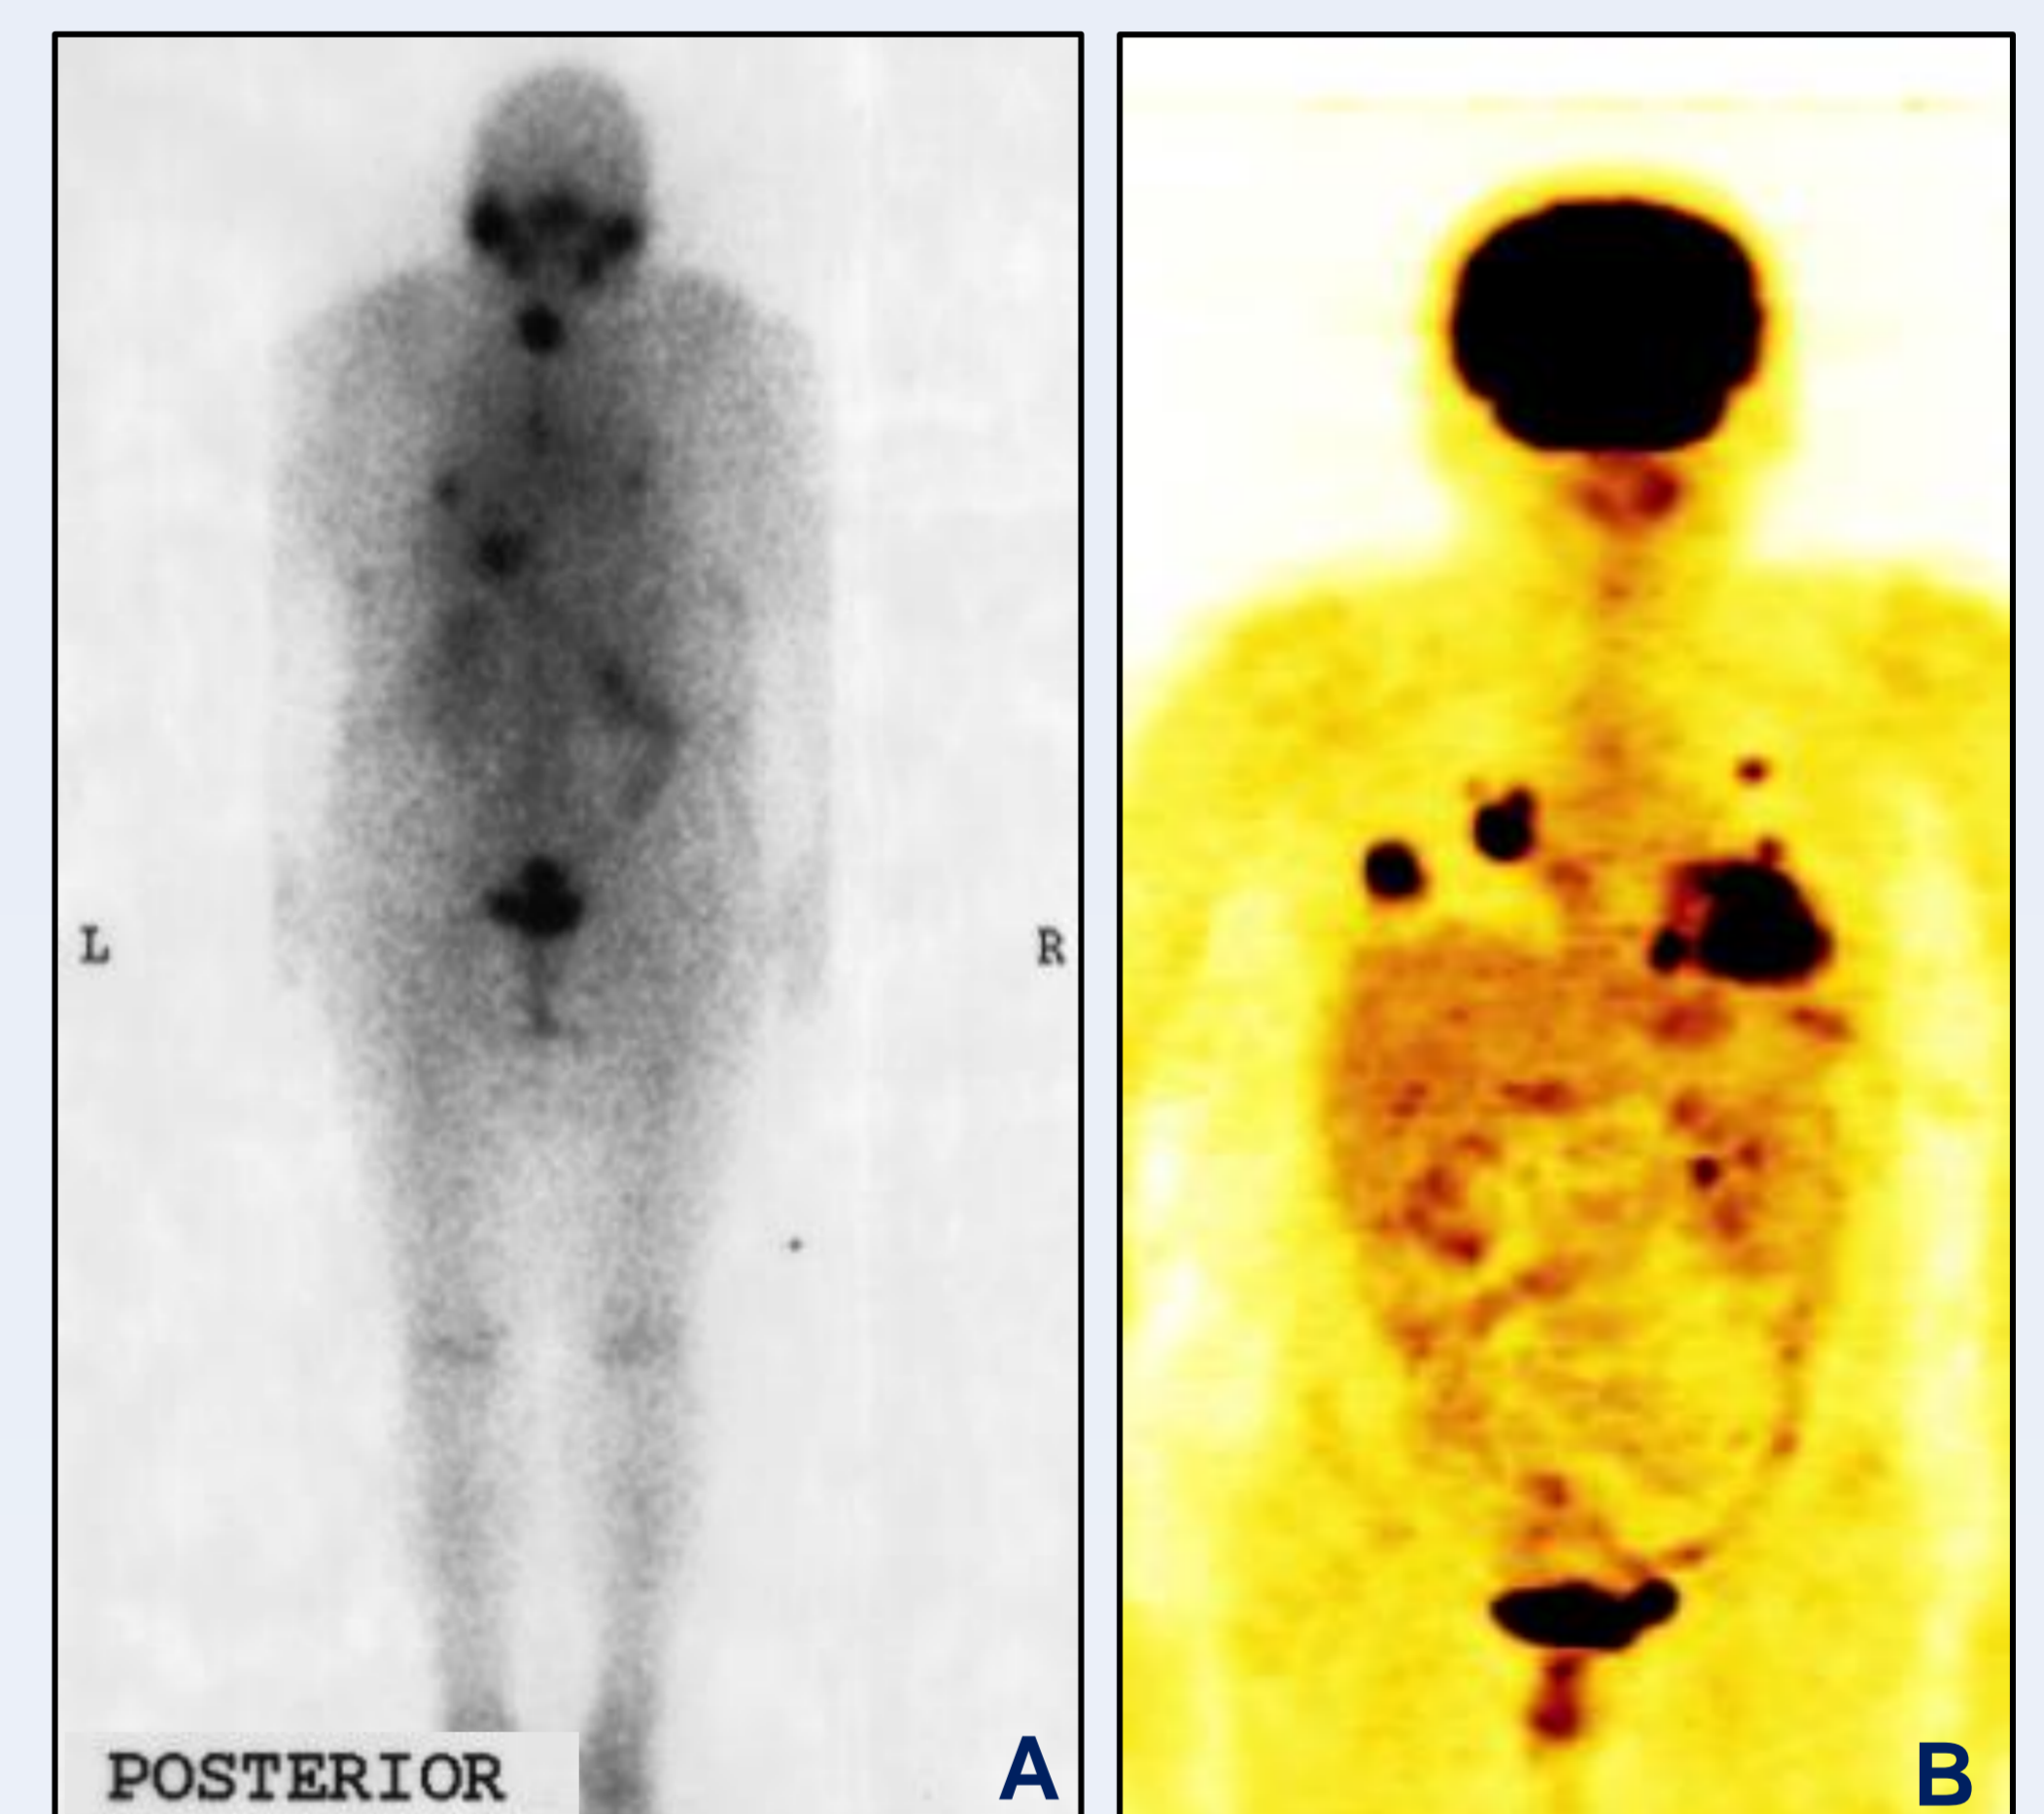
Post-radioiodine whole-body scan showing iodine-avid lung lesions (A); FDG-PET scan showing uptake in the lung metastasis (B).
